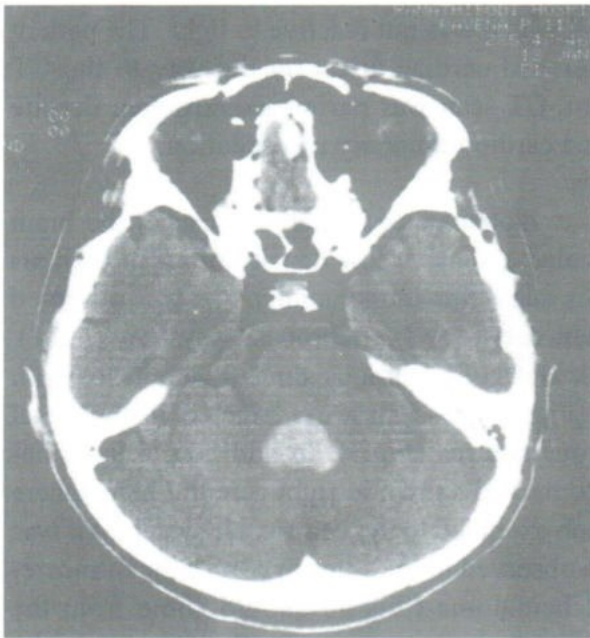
NCE axial CT scan of the brain showed air in the cavernous sinuses. (The hematoma in the 4th ventricle is observed.)
